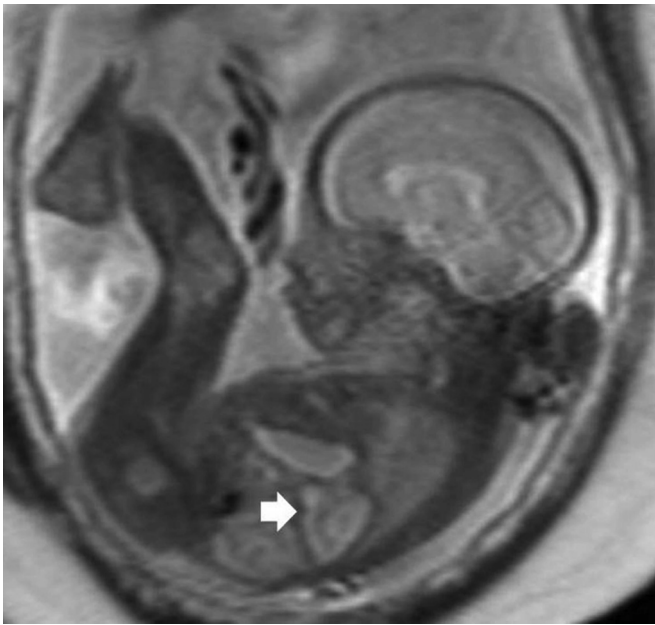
Fetal magnetic resonance imaging reveals a mass with cystic spaces (arrow) located cranial to the left kidney.
